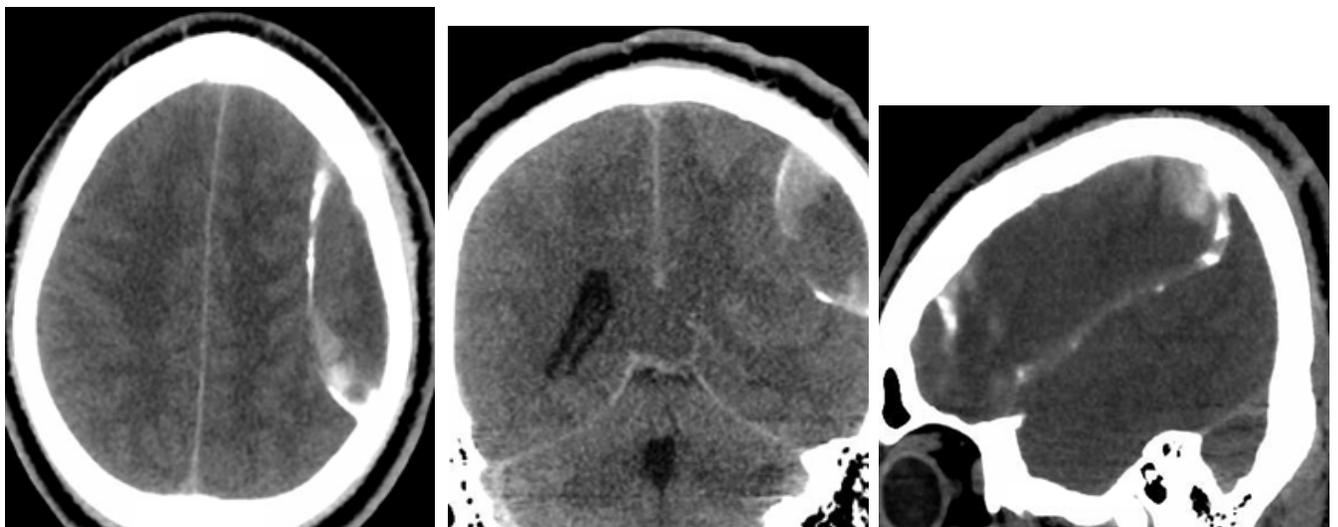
Post-procedure CT head (axial, coronal, and sagittal views) depicting the contrast enhancement of the subdural hematoma and the capsule. (CT: Computed tomography).
